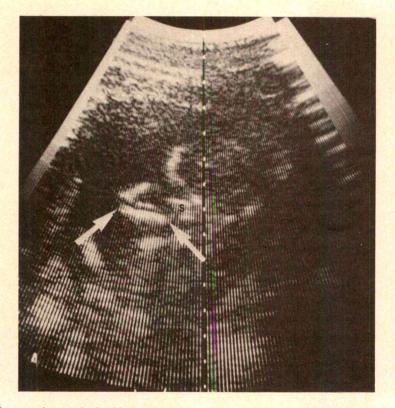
Ultrasound scan of a fetal femur at 22 weeks' gestation (arrows).
